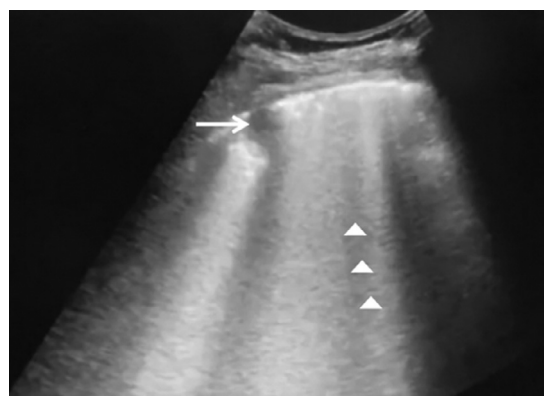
Ultrasound image of a critical coronavirus disease 2019 (COVID-19) patient identifying a C-line sign (arrow) and diffused B line (arrowhead).
